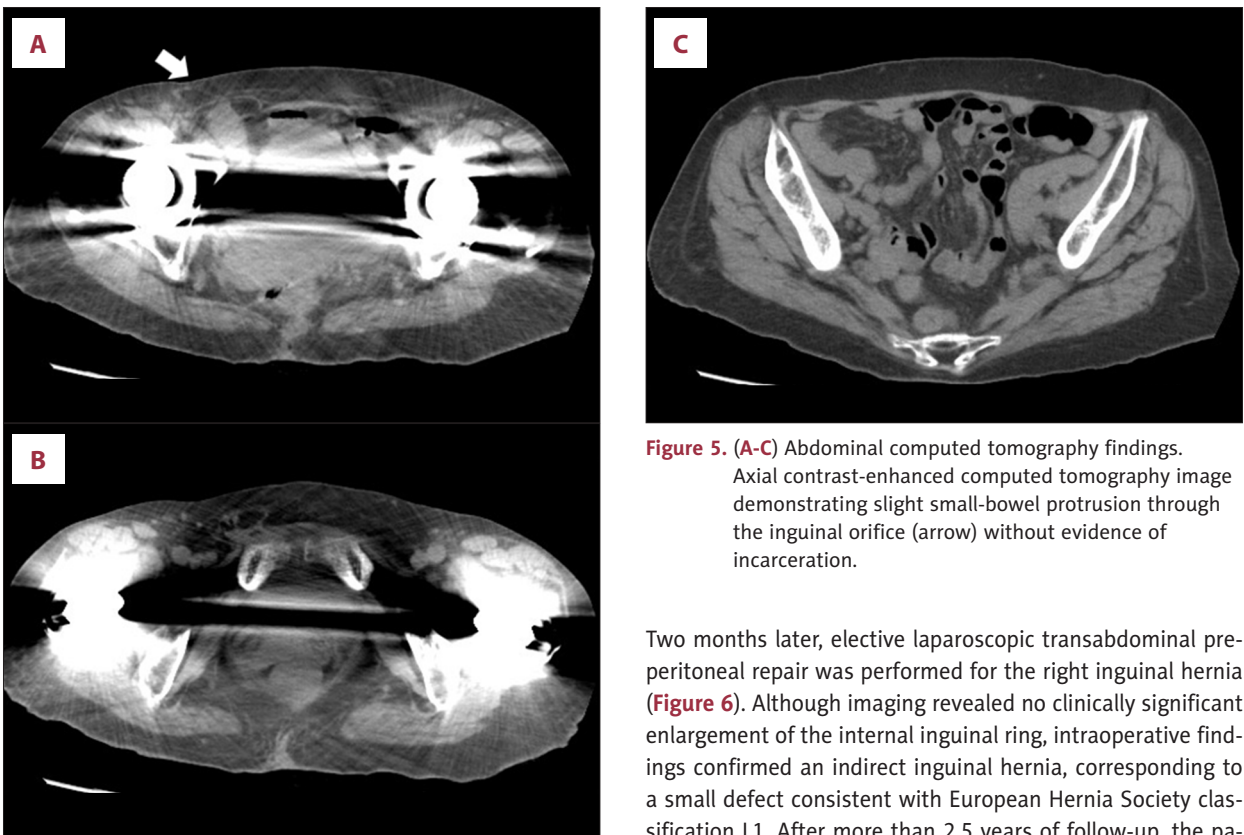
(A-C) Abdominal computed tomography findings. Axial contrast-enhanced computed tomography image demonstrating slight small-bowel protrusion through the inguinal orifice (arrow) without evidence of incarceration.
